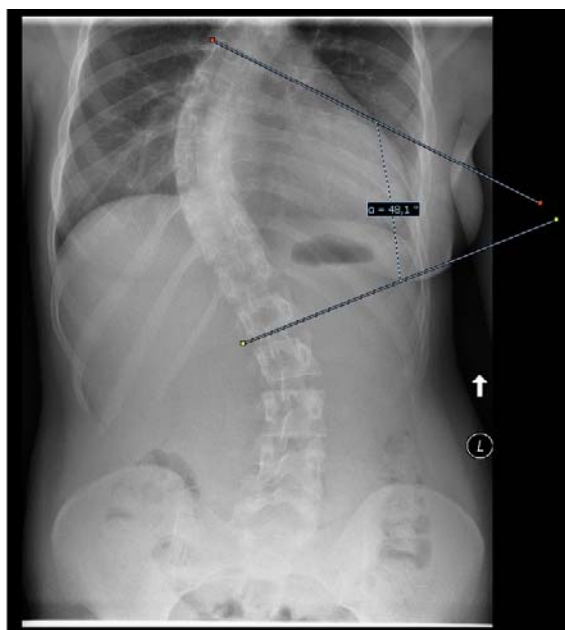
X-ray of 19 year's old patient with idiopathic scoliosis before surgery (48.1° of cobb angle)
